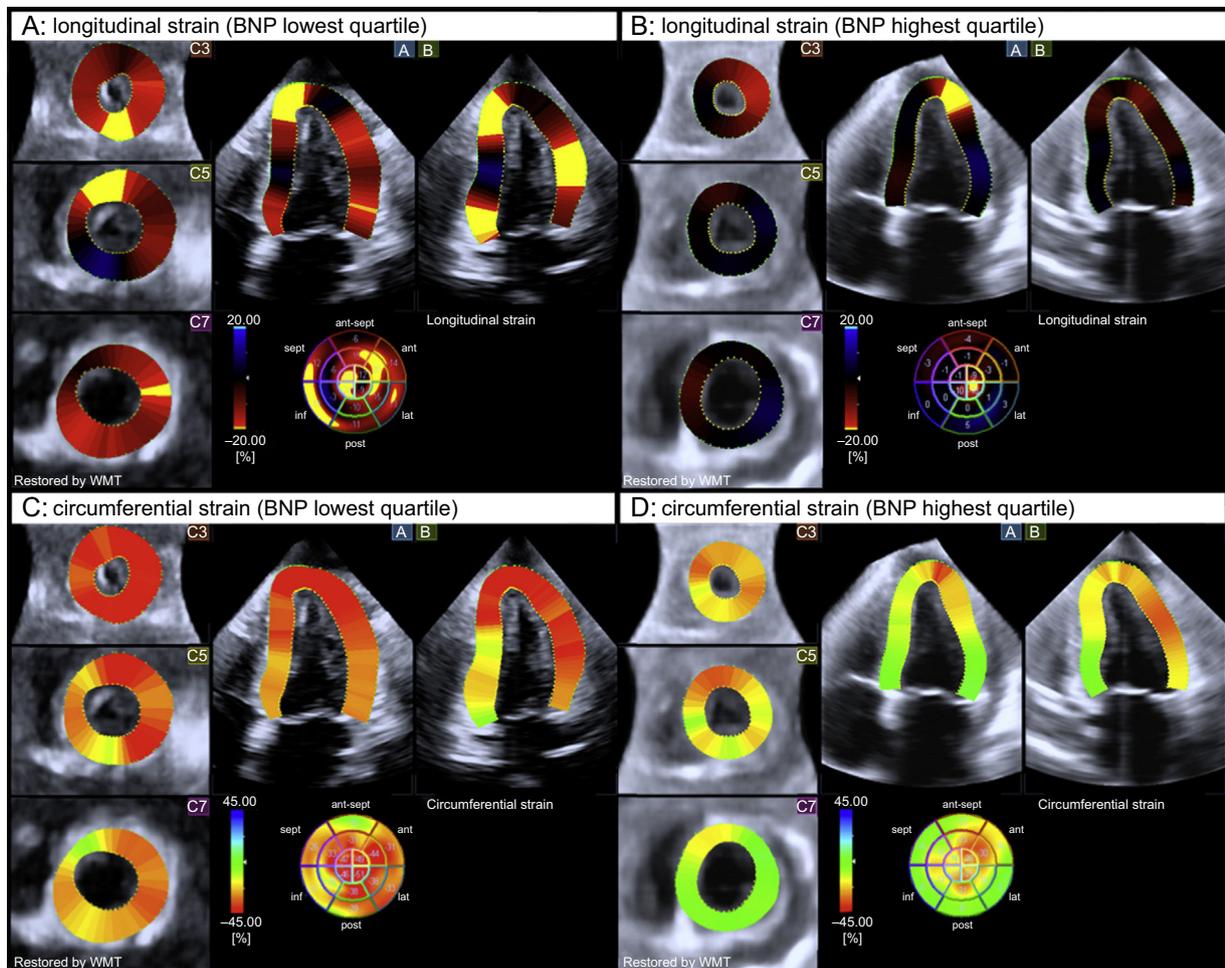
End-systolic left ventricular global longitudinal strain and circumferential strain color-coded 3-dimensional-speckle tracking echocardiography performances in 2 patients with brain natriuretic peptide levels at the lowest (A and C) and the highest (B and D) tertiles. Note the significantly altered myocardial mechanics of the left ventricle in the patient belonging to the highest brain natriuretic peptide level tertile (B and D) according to the color-coded bar. BNP, brain natriuretic peptide. WMT, wall motion tracking.
